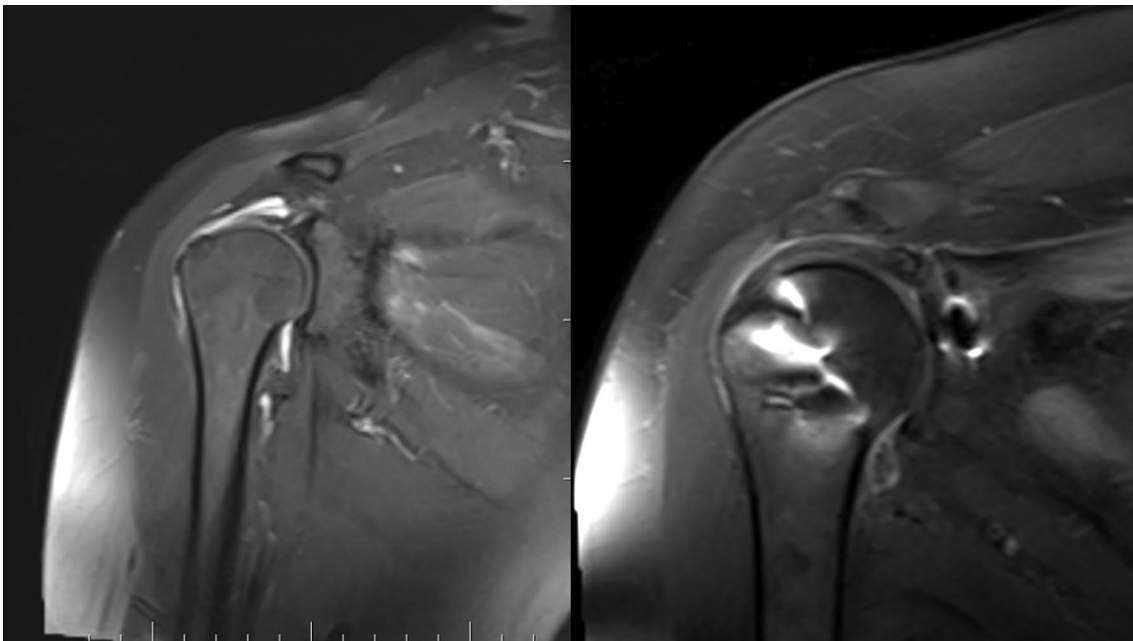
Preoperative (left) and postoperative (right) MRI of the patient who underwent an SCR procedure
